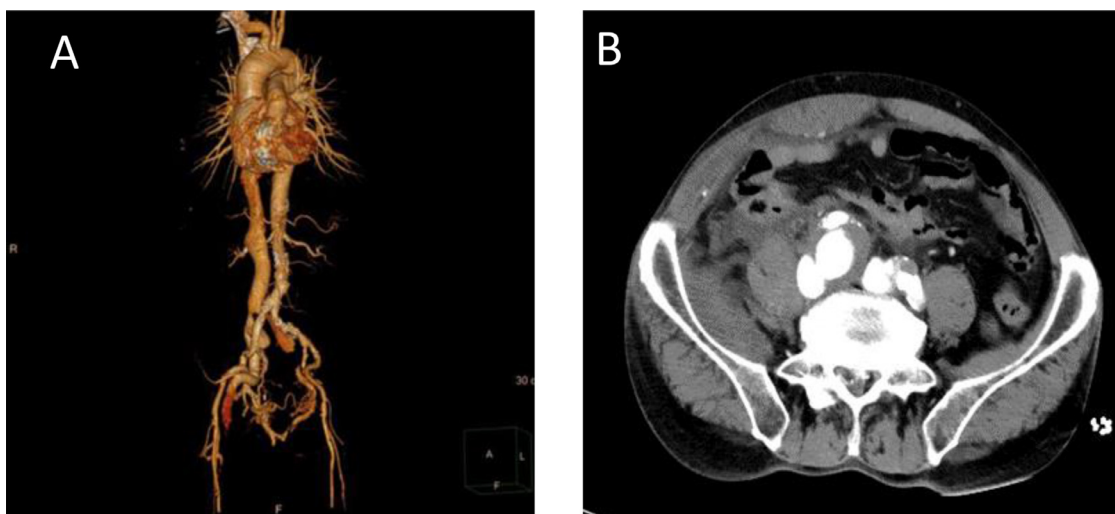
Initial CTA shows the right common iliac aneurysm, bilateral iliac vein, and inferior vena cava opacified at the same time, suggesting an arteriovenous fistula.
